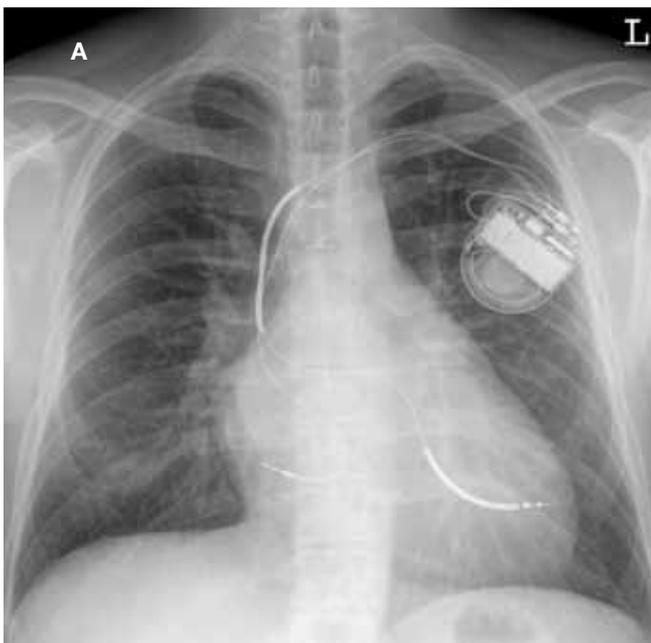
A & B. Posterior-anterior and lateral chest roentgenogram of dual-chamber pacing leads in D-TGA status post-Mustard operation. Note the left-sided subpulmonic ventricular lead.
